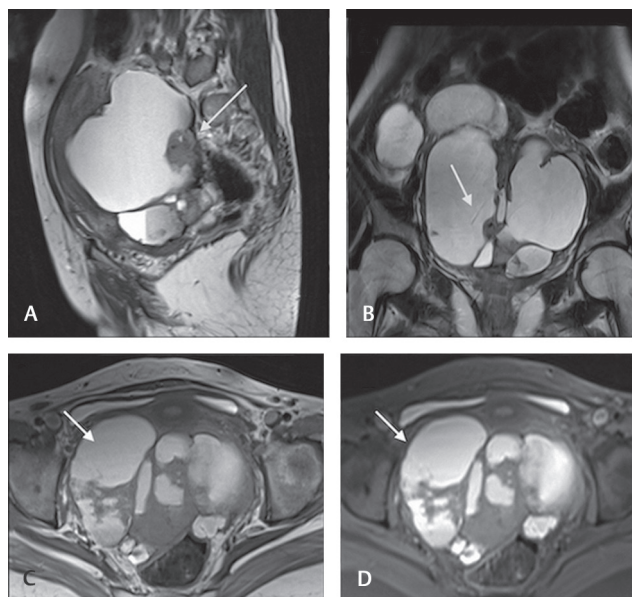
(A–D) T2W sag (A), cor (B), and T1W axial images without and with FS (C and D), showing an endometrioma (arrows in C and D) with absence of T2W shading and a solid mural nodule (arrows in A and B) suggestive of malignant transformation. FS, fat-suppressed; T1W, T1-weighted; T2W, T2-weighted.
